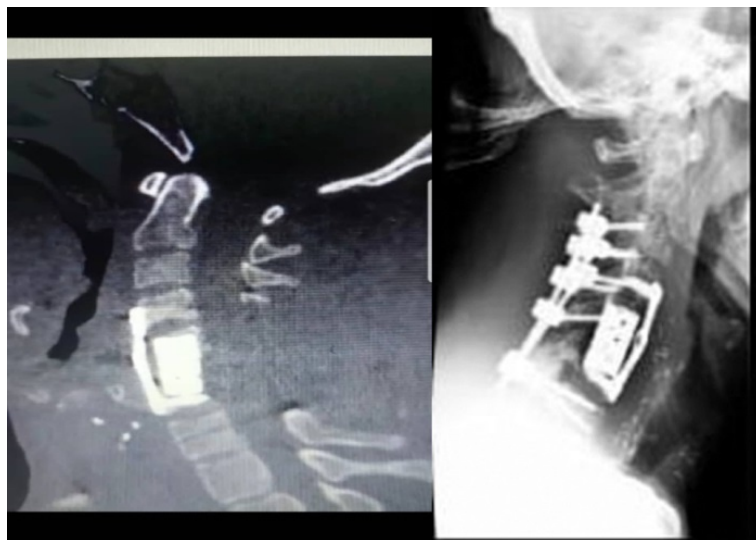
Post operation CT scan indicating relieved spinal cord.
